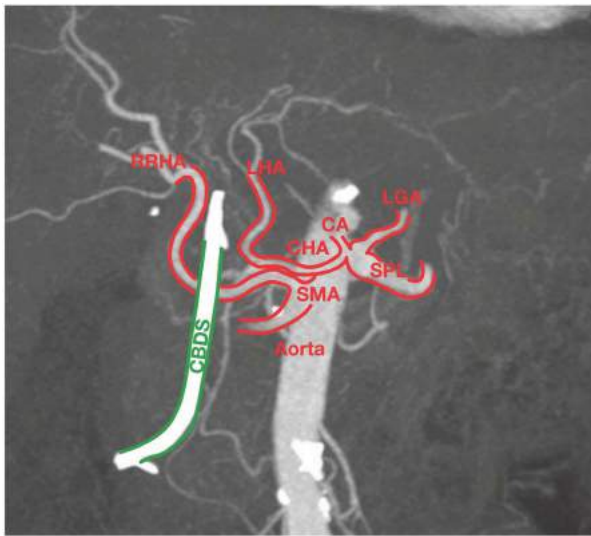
• A CT angiogram showing a replaced right hepatic artery (RRHA) coming off the SMA. A stent (CBDS) is seen in the common bile duct, which shows the anatomical relationship of the RRHA as it passes behind the common bile duct and portal vein (not shown).
